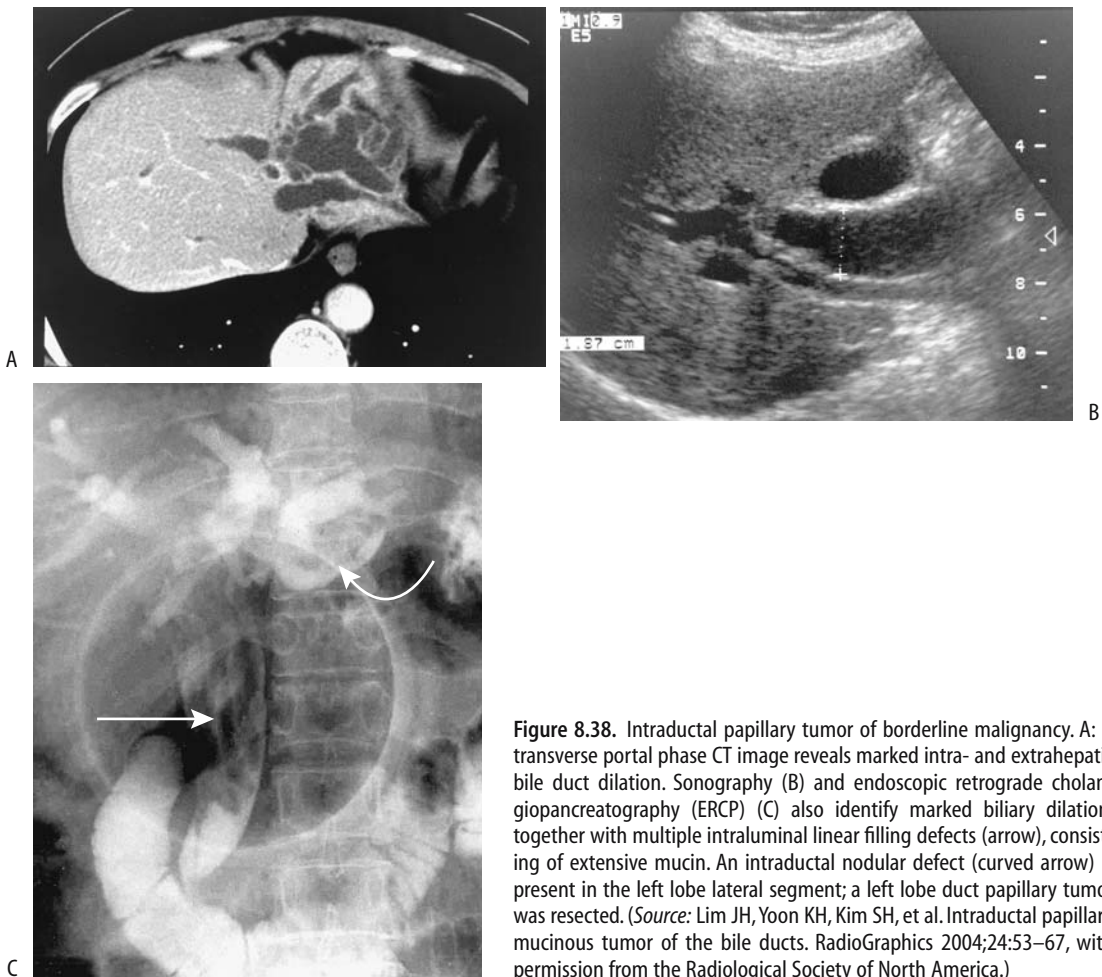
Intraductal papillary tumor of borderline malignancy. A: A transverse portal phase CT image reveals marked intra- and extrahepatic bile duct dilation. Sonography (B) and endoscopic retrograde cholangiopancreatography (ERCP) (C) also identify marked biliary dilation, together with multiple intraluminal linear filling defects (arrow), consisting of extensive mucin. An intraductal nodular defect (curved arrow) is present in the left lobe lateral segment; a left lobe duct papillary tumor was resected. (Source: Lim JH, Yoon KH, Kim SH, et al. Intraductal papillary mucinous tumor of the bile ducts. *RadioGraphics* 2004;24:53–67, with permission from the Radiological Society of North America.)
